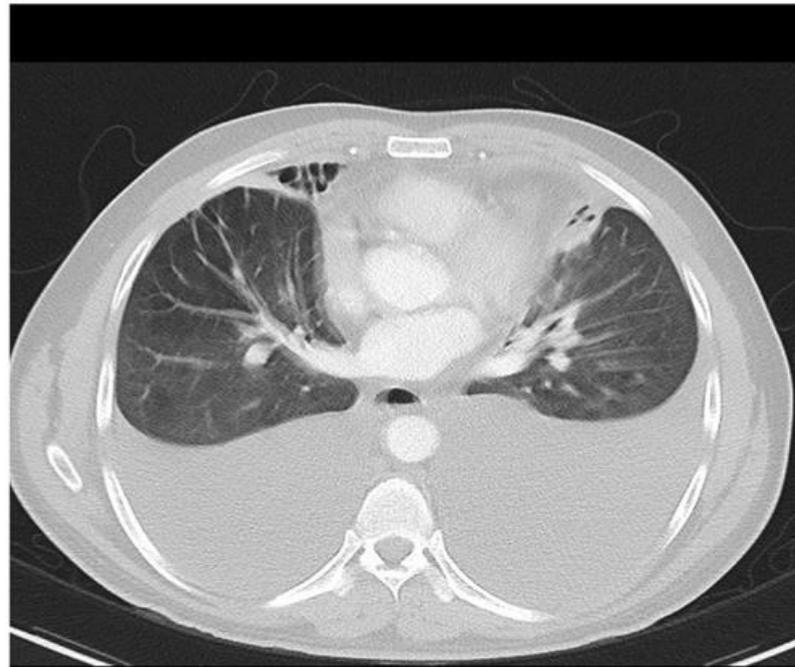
Computed tomography (CT) of the chest demonstrating bilateral pleural effusions. Image courtesy of Paul Leong, Radiopaedia.org, rID: 26474.
